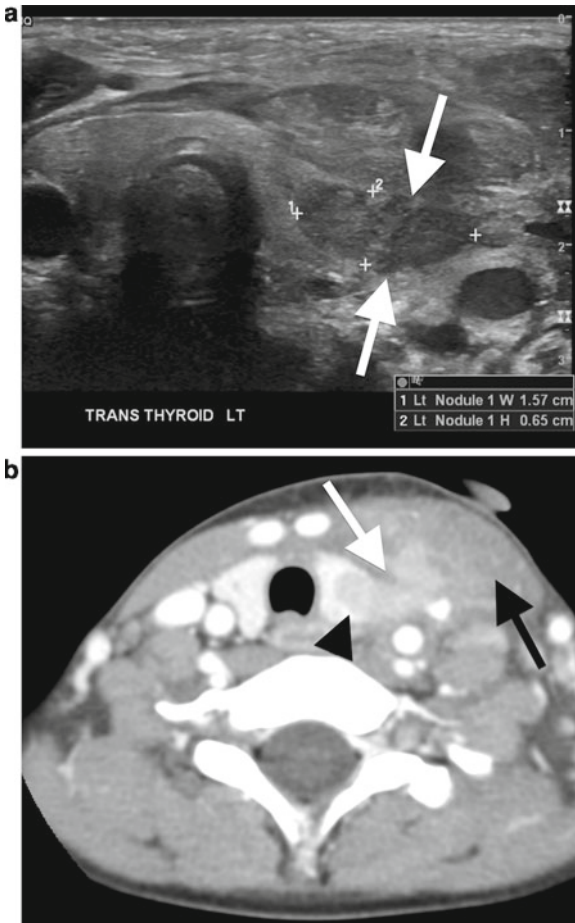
Fourth branchial apparatus anomalies. Suppurative thyroiditis in a 6-year-old boy with fever and neck pain. Embryologic remnants from the fourth branchial apparatus are almost always left-sided and may lead to any one of several abnormalities, from suppurative thyroiditis to a sinus track to infected cysts or abscesses. In this child, transverse US shows a well-defined, focal, heterogeneously hypoechoic nodule (*calipers, a*) extending through the thyroid capsule (*arrows, a*). Axial CT in the same patient also shows the focal area of suppuration in the upper pole of the left lobe (*arrowhead, b*) as well as more detail of the extracapsular extension (*white arrow, b*) and inflammation of the overlying strap musculature (*black arrow, b*).
